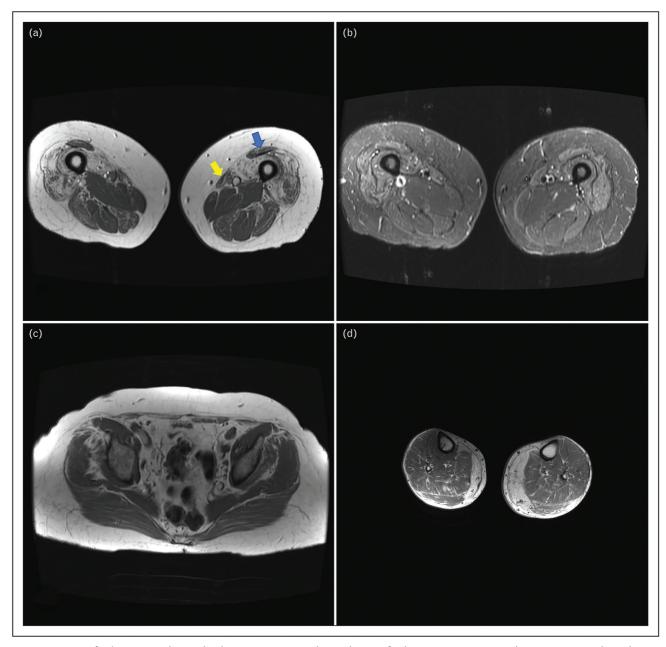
MRI findings in inclusion body myositis. Typical muscle MRI findings in IBM: T1 axial images (a, c, d) and FSE-IR sequence (b). (a) Atrophy and fatty replacement of the distal quadriceps, predominantly involving the vastus medialis and lateralis, worse on the right, with sparing of the rectus femoris (blue arrow) and involvement of the sartorius (yellow arrow). In contrast, there is relative sparing of pelvic muscles (c) and more proximal parts of the quadriceps creating a proximal to distal gradient in the quadriceps (not shown). Increased water content in distal quadriceps (b) indicating inflammation (equivalent to a T2 sequence). In the leg compartment, there is prominent involvement of the medial gastrocnemius (d).
